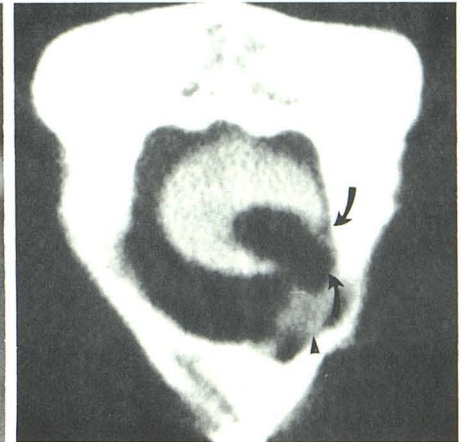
CT metrizamide myelogram shows herniation of spinal cord through posterolateral dura (arrows) associated with extravasation of metrizamide (arrowhead).
